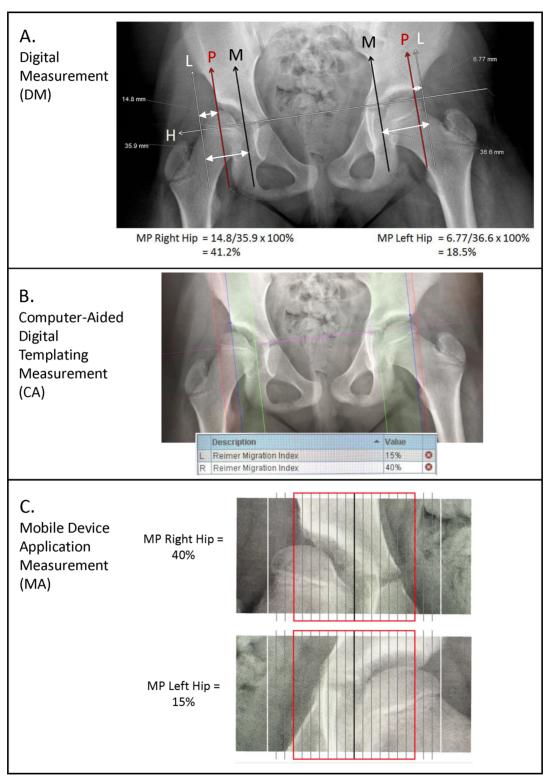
Three methods of measurement of migration percentage: (a) digital measurement (DM). Hilgrenreiner's Line (H), Perkin's Line (P) and the medial (M) and lateral (L) edges of the ossific nucleus of the femoral head are drawn to measure the appropriate distances and calculate the MP of each hip; (b) computer-aided digital templating measurement (CA). A digital templating tool allows for manipulation of each line to the appropriate position on the radiograph, and the MP is automatically calculated by the tool; (c) mobile device application measurement method (MA). Using the touchscreen of the device, each hip is expanded and positioned on the MP ruler so that vertical lines divide the femoral head into 10% increments, allowing for determination of MP of each hip without measurement of distance.
